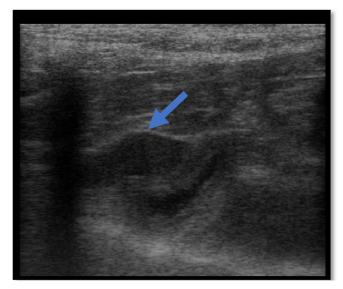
Ultrasonograpy of normal pancreas (arrow) - Isoechoic or hypoechoic to the surrounding mesentry
